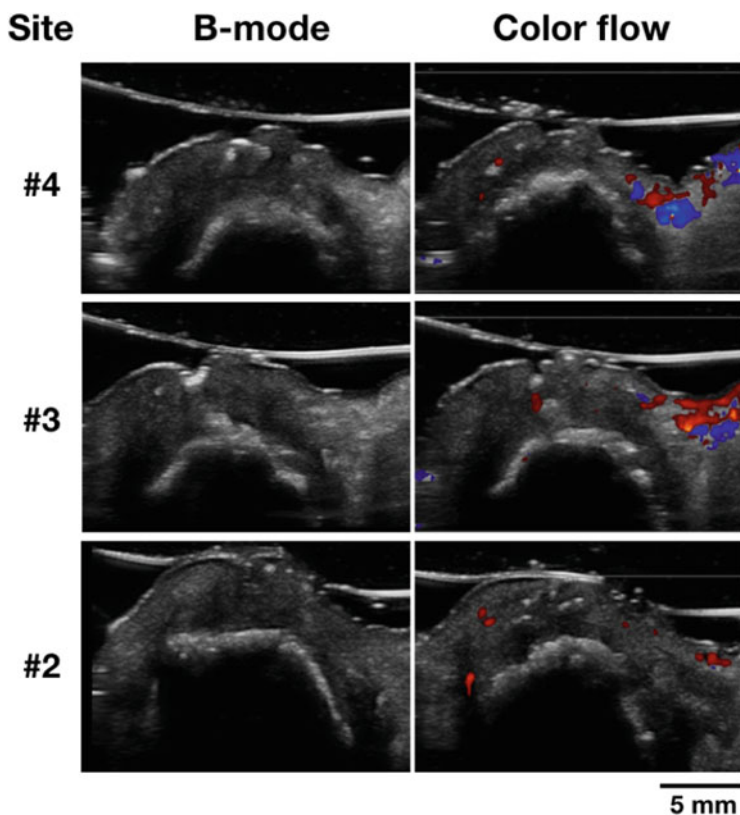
Ultrasound occlusal images of the same case at 1 month after the membrane was removed. On the B-mode images, residual particles are less visible in the soft tissues. Color flow images show normal blood flow, compared to Fig. 9.5, indicative of resolution of inflammation
